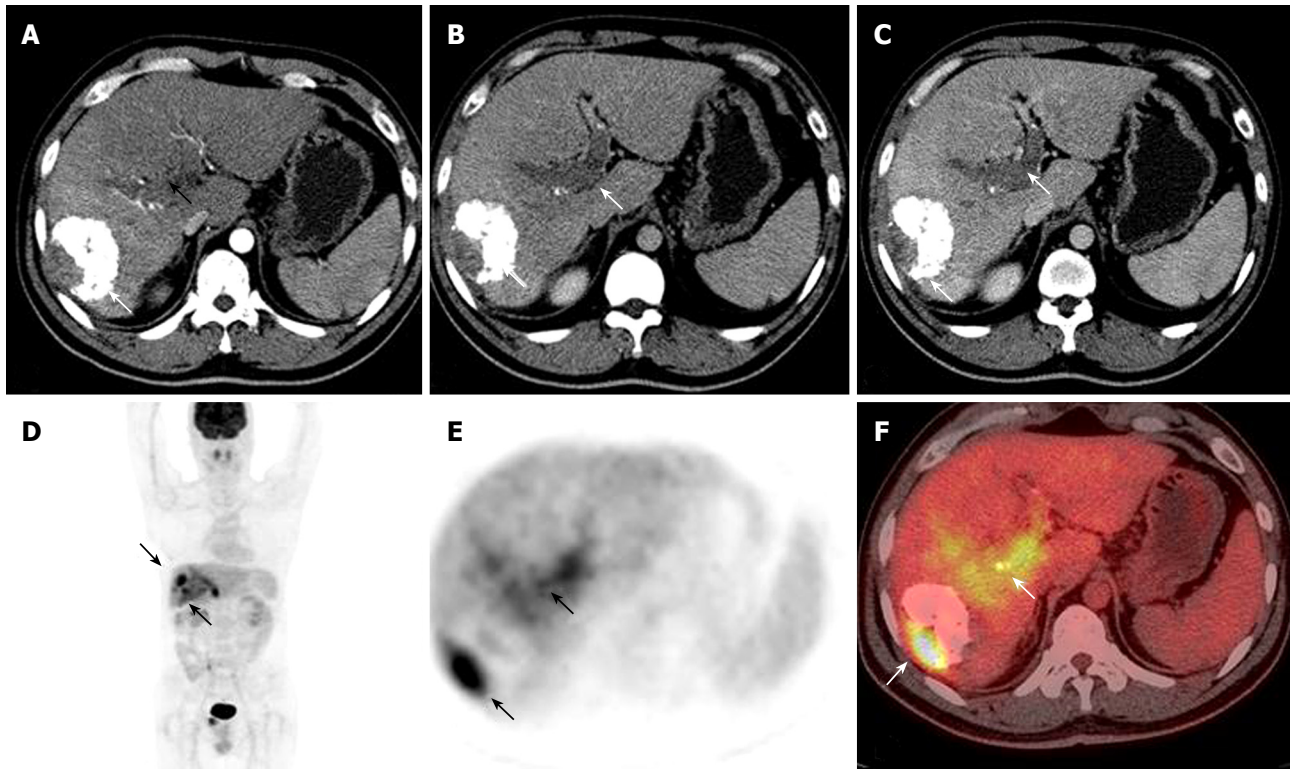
A 38-year man, who had TACE 1 mo before, underwent PET/CT to monitor response to the treatment. Contrast-enhanced arterial-phase axial CT image showed the mass with partial accumulation of iodized oil in the right lobe of the liver (arrows, A, B). A filling defect was detected in the left branch during the portal phases (arrow, C). PET and PET/CT fused images (arrows, D, E and F) revealed residual viable tumor and a highly metabolically active tumor thrombus in the left branch of the portal vein.
